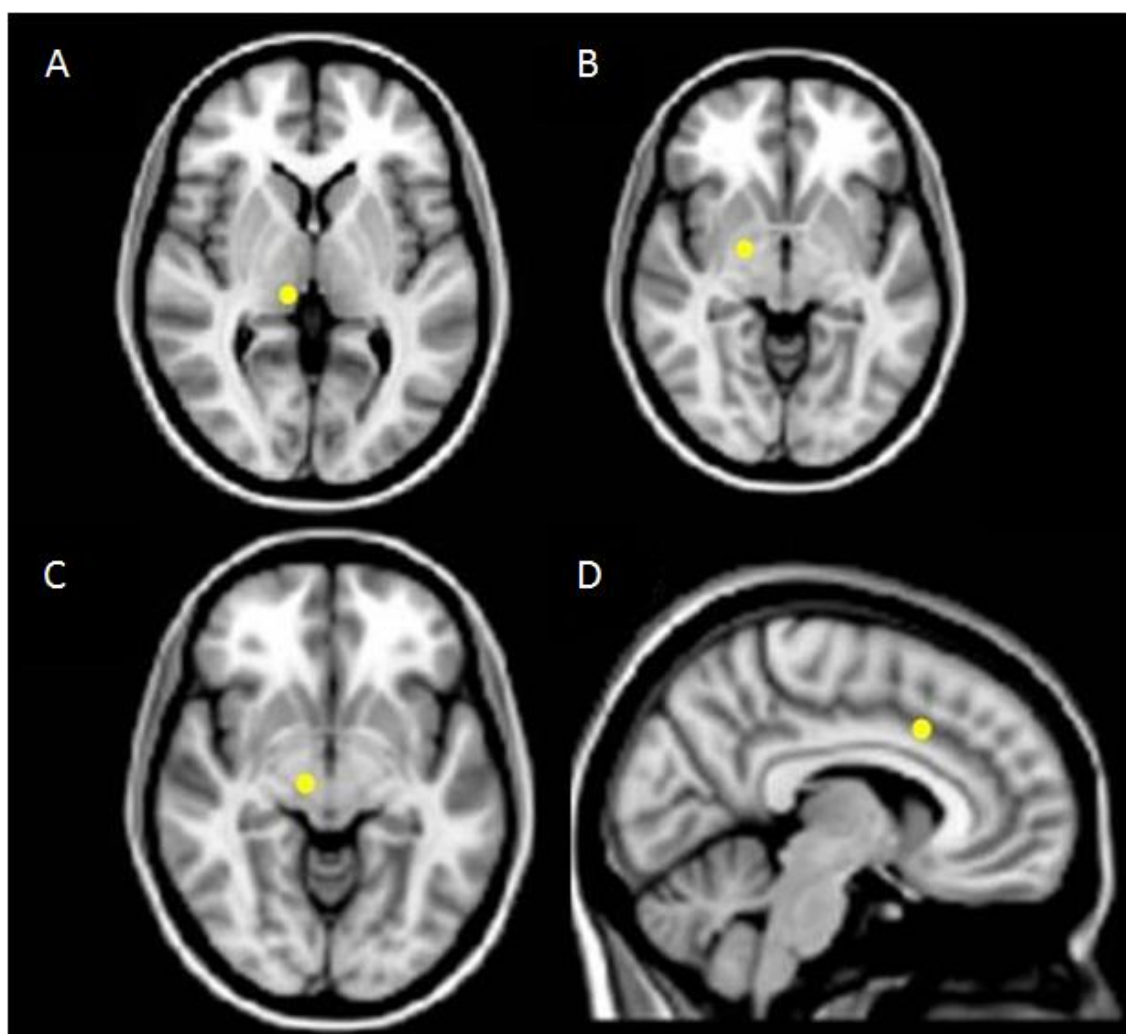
Post-operative images (post-operative CT scans fused to pre-operative MRI scans) showing target sites for electrodes being implanted in (A) the ventroposterolateral nucleus of the sensory thalamus, (B) the internal globus pallidus, (C) the subthalamic nucleus, and (D) the anterior cingulate cortex.
